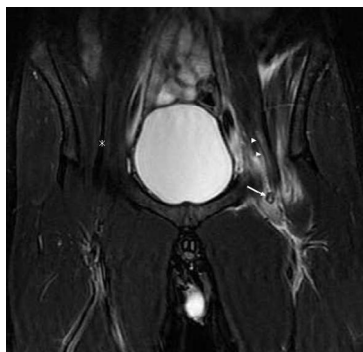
STIR coronal hips MRI at level of pubic symphysis. Both the left psoas major tendon (white arrow) and myotendinous junction (arrowheads) show partial high signal intensity suggestive of tear. The right psoas major tendon (asterisk) is normal.
